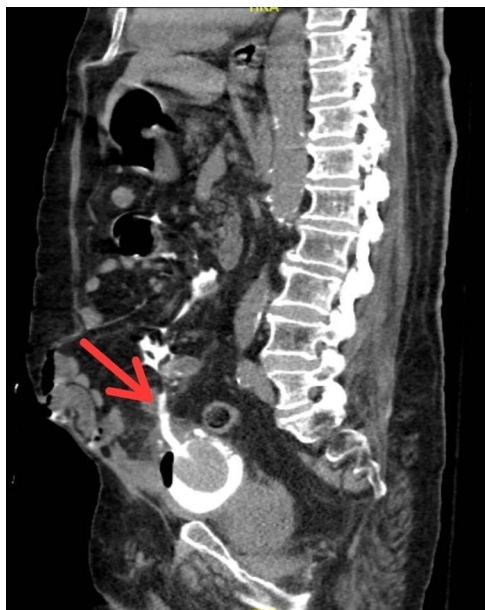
Sagittal view of CT scan showing Foley catheter protruding into peritoneal cavity.
